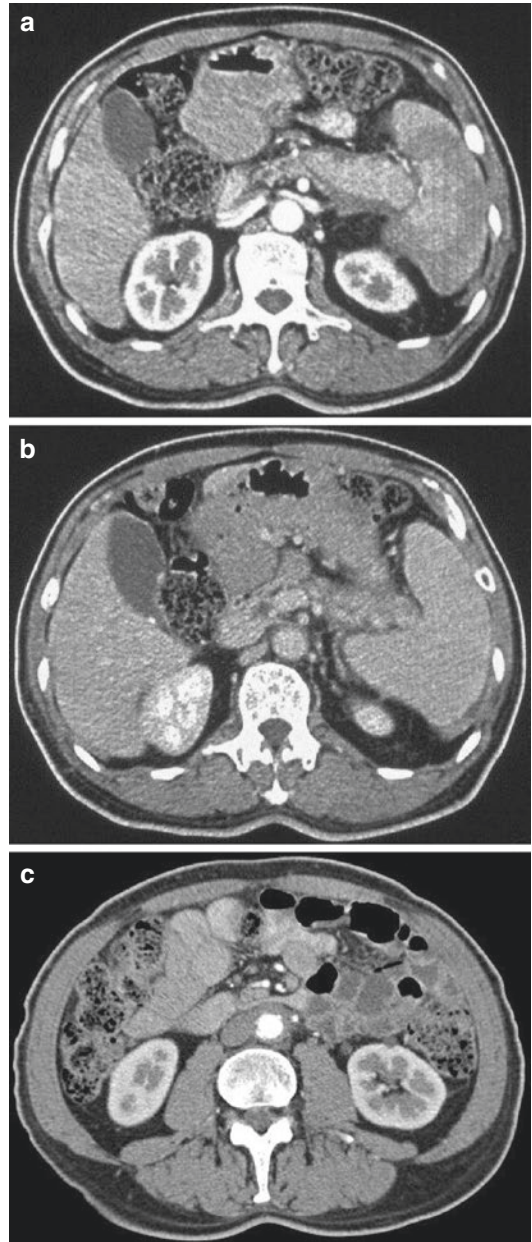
CT showed normal morphology of pancreas, improvement of gastric varices and the compression of abdominal aorta
